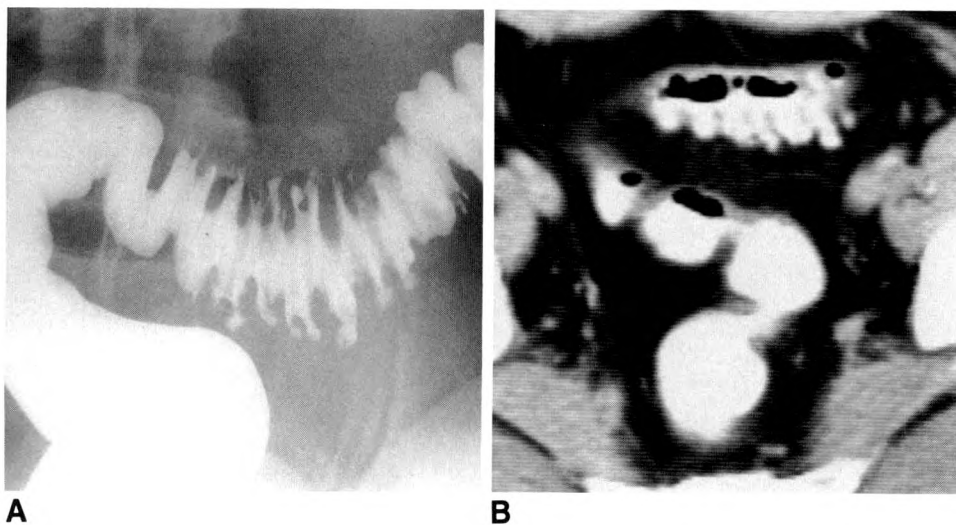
False-negative contrast enema/CT.
